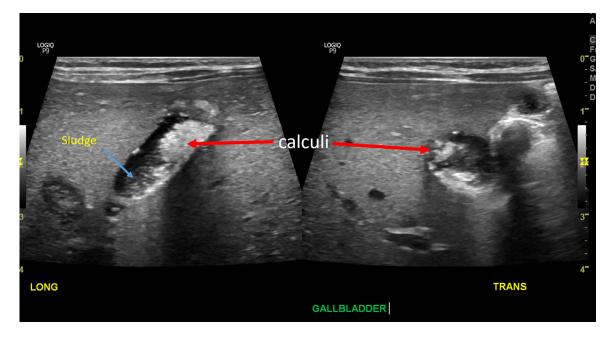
Ultrasound images of the gallbladder showing sludge (blue arrow) and calculi (red arrows) associated with acoustic shadows in the longitudinal and transverse planes.
